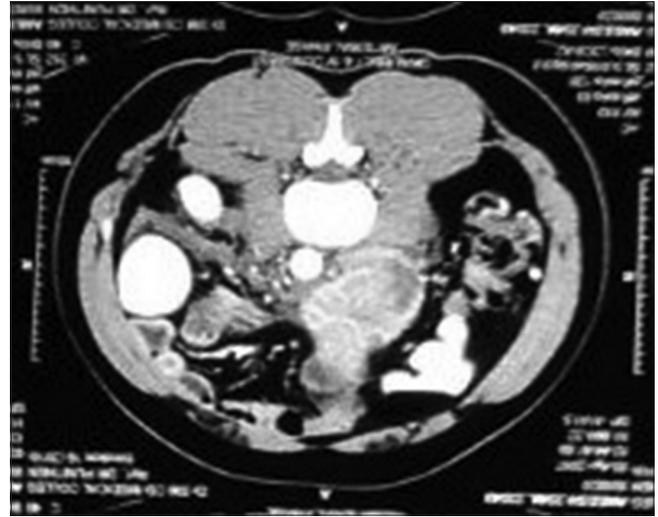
Computed tomography solid cystic mass in paraaortic region
